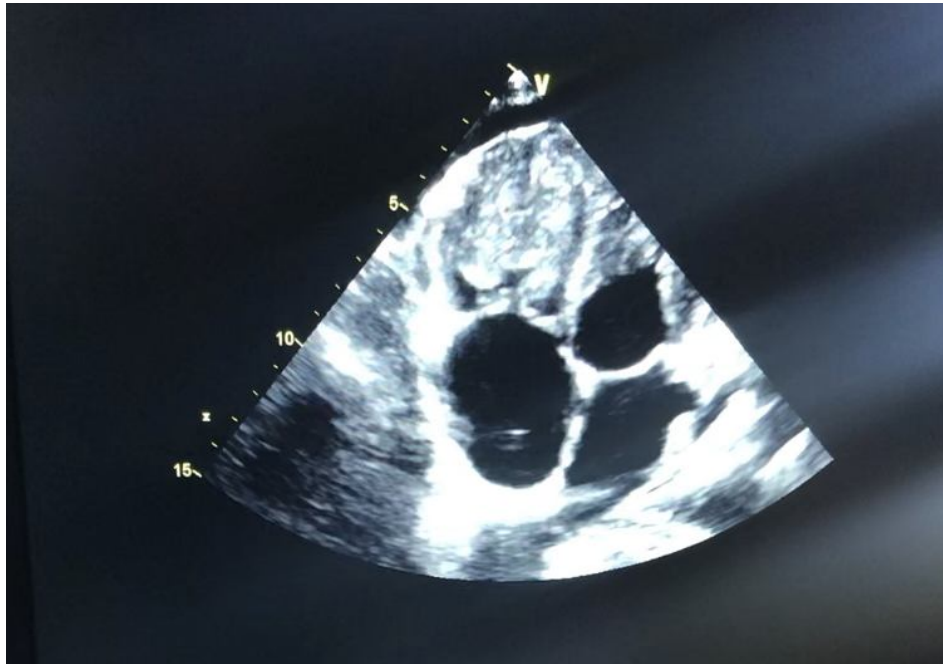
Apical 4 chamber view echocardiography showing the mass occupying the entire RV
